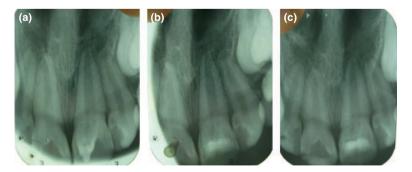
(a) Radiograph showing talon cusp with incomplete root formation (b) Postoperative radiograph (c) Twelve months post-treatment.
